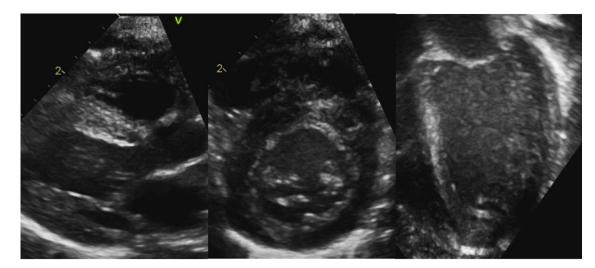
Transthoracic two-dimensional echocardiogram views of an infant with concentric left ventricular hypertrophy secondary systemic hypertension from renal disease. View include parasternal long axis (left), short axis (middle), apical four chamber (right).
